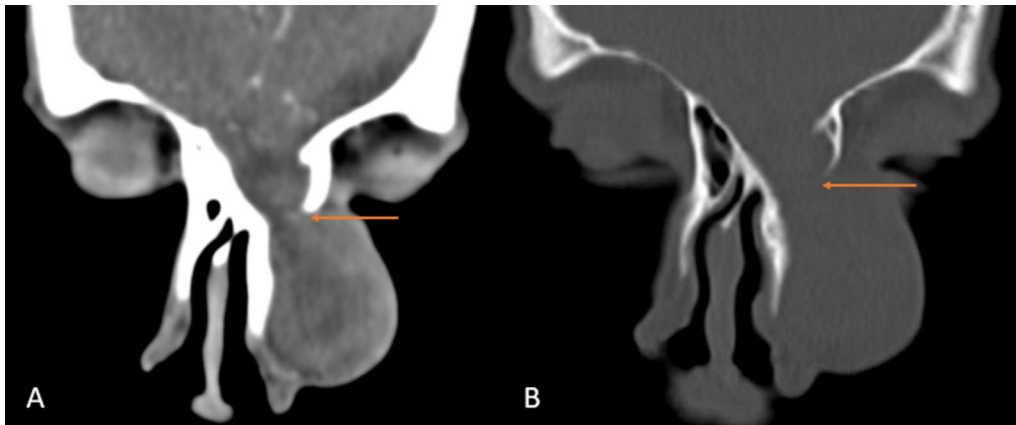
Coronal CT PNS brain window (A) and bone window (B) showing herniation of the part of the left frontal lobe and CSF extending till the left lateral nasal bone through a defect in the left cribriform plate giving heterogeneously hypodense appearance to the herniated tissue (arrow)
